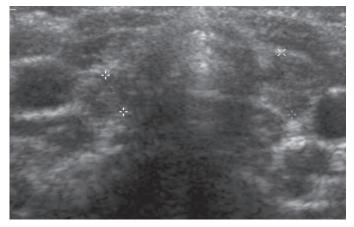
Thyroid ultrasound image of child Aa:9 with thyroid disintegration, showing decreased echogenicity and inhomogeneous echotexture.
